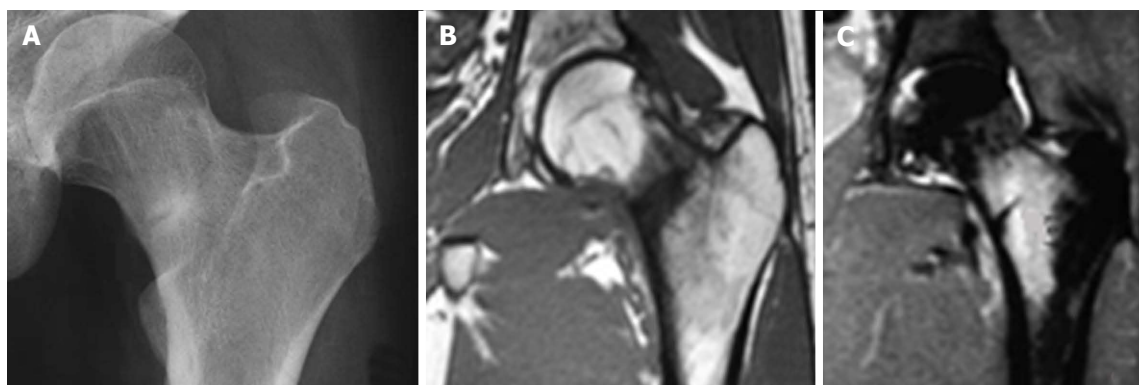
The management of an undisplaced compression sided femoral neck stress fracture. A: Diagnostic antero-posterior radiograph; B: Diagnostic T1 sequence coronal-plane magnetic resonance imaging (MRI) view; C: Diagnostic short tau inversion recovery sequence coronal-plane MRI view.
